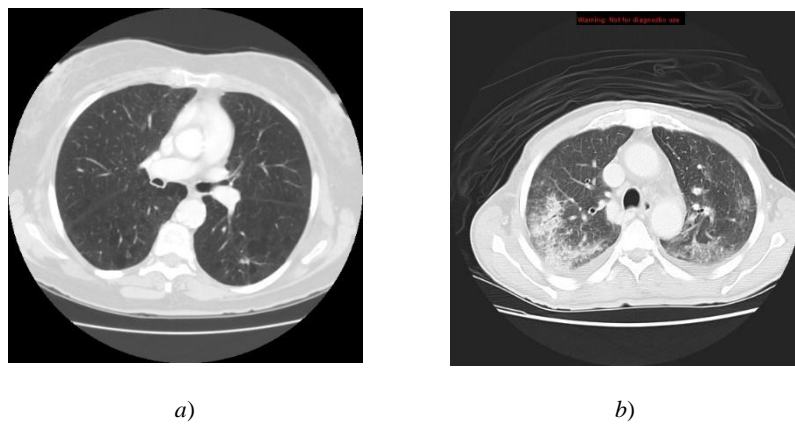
Lung CT slices in the axial view: *a* — healthy CT lung scan; *b* — pathological CT lung scan
